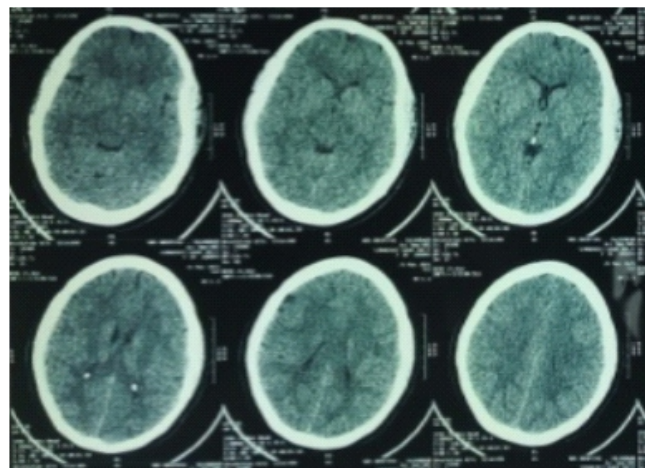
Non-contrast CT brain (axial sections) showing features suggestive of early mild diffuse cerebral edema, evidenced by subtle reduction in gray–white matter differentiation and mild effacement of cortical sulci without significant midline shift or ventricular compression.
